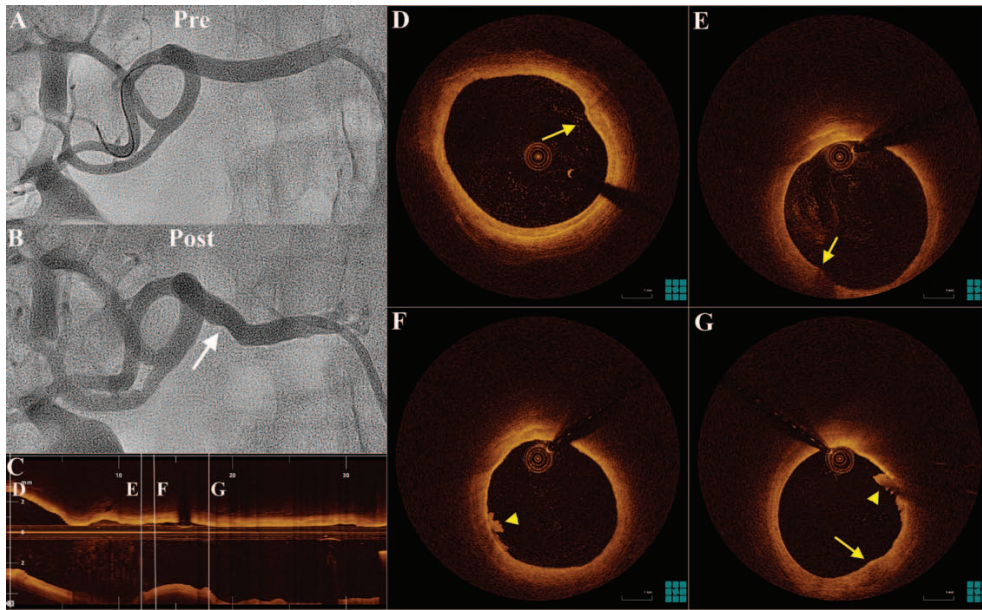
Renal artery trauma after nonballoon catheter denervation. A and B, Renal angiography predenervation and postdenervation with the Symplicity system. White arrow indicates lumen contour irregularities in the postdenervation angiogram. Minimal lumen area by intravascular ultrasound was reduced from 13.65 to 10.54 mm², whereas percent atheroma volume was increased from 23.5% to 26.0%. C–G, Optical coherence tomography images demonstrating edema (yellow arrows) and thrombus (yellow arrowhead) at multiple sites.
